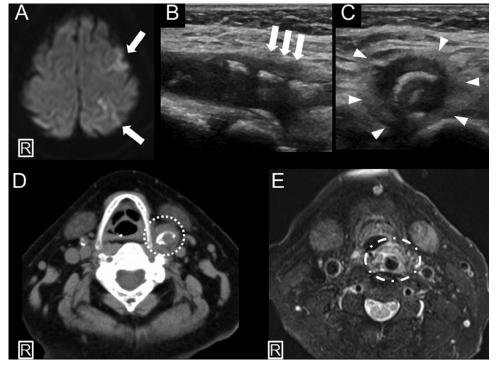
Diffusion-weighted brain magnetic resonance imaging (MRI) revealing high-intensity areas in the left frontal and parietal lobes (arrows) (A). Longitudinal B-mode carotid ultrasonography demonstrating a calcified plaque with swelling of the vessel wall at the bifurcation of the left common carotid artery (LCCA) (arrows) (B). Transverse B-mode imaging showing hypoechoic soft tissue surrounding the area (arrowheads) (C). Noncontrast cervical computed tomography showing isodense tissue surrounding the bifurcation of the LCCA (dotted circle) (D). Fat-saturated T2-weighted cervical MRI revealing high-intensity areas around the bifurcation of the LCCA that is transposed to a retropharyngeal location (dashed circle) (E).
